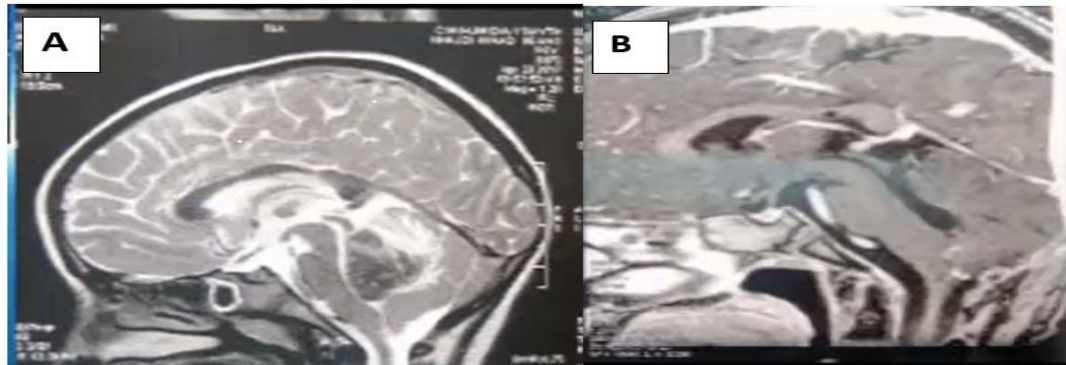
SAGITTAL BRAIN MRI SHOWING A LESION FILLING THE FOURTH VENTRICLE, TREATED WITH TOTAL RESECTION.
